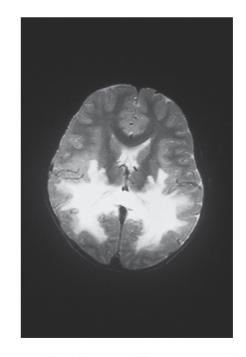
MRI of the brain of GQ, a seven-year-old boy with ALD. He had experienced the sudden onset of seizures after a period of disturbed behavior. He had pyramidal tract signs and spatial agnosia. Imaging revealed the typical white matter disease.
